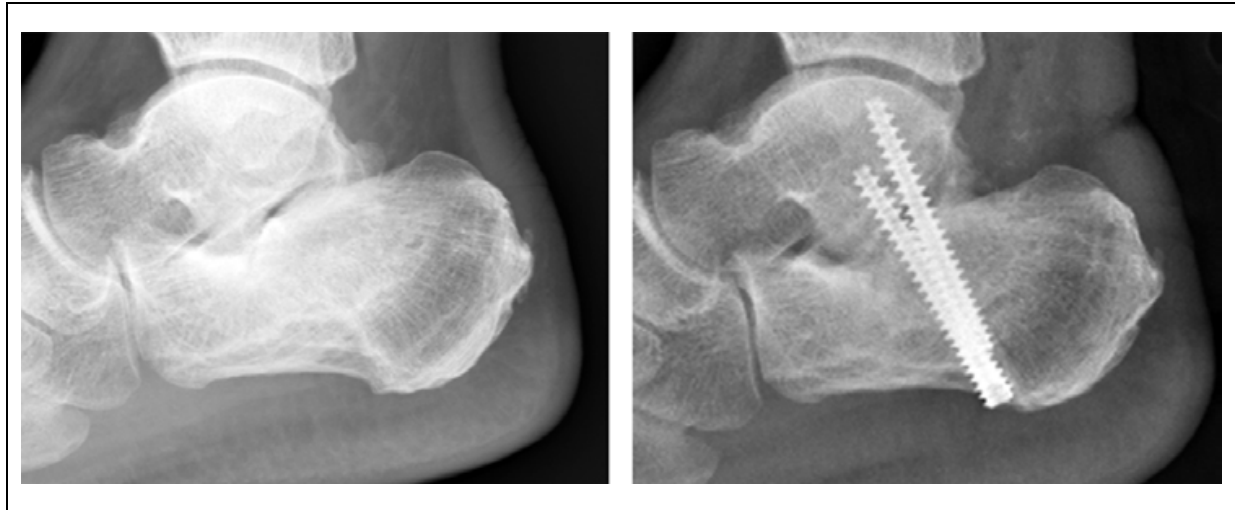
Lateral view of the standard X-ray of the ankle before surgery (left) and after surgery (right).
